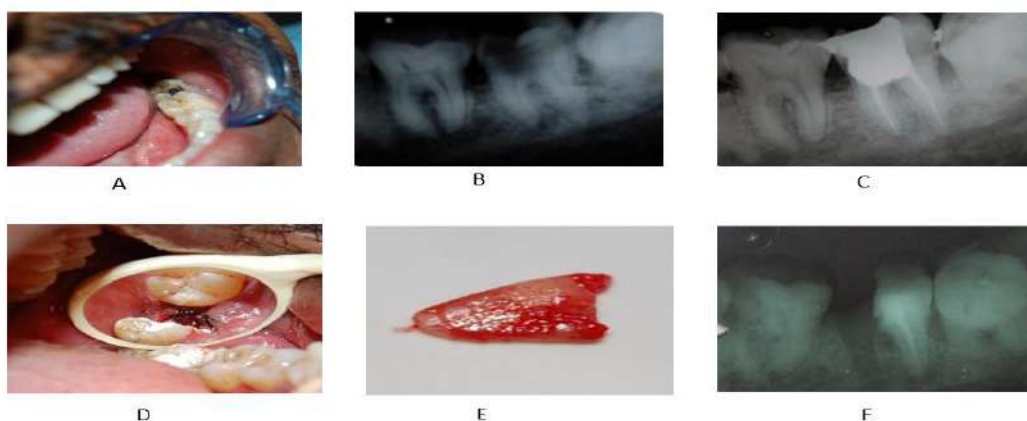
A) Pre-operative B) Caries involving furcation vertical & bone loss around mesial root C) obturation of roots D) Vertical cut towards the bifurcation area E) Amputation of mesial half F) Radiograph showing retained distal
